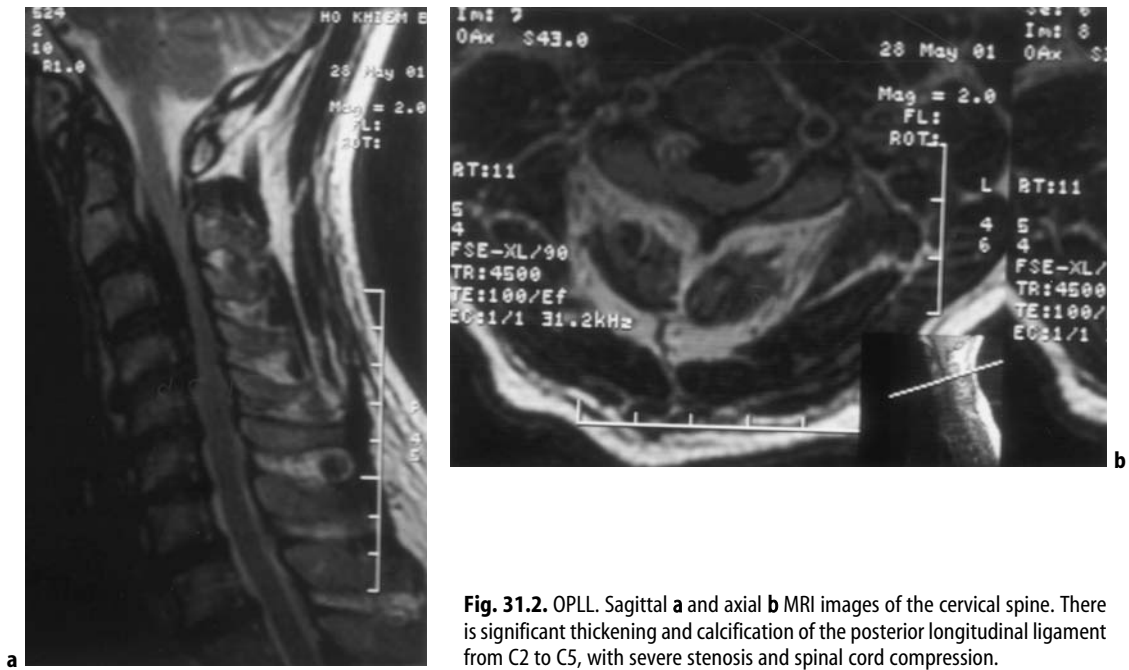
OPLL. Sagittal a and axial b MRI images of the cervical spine. There is significant thickening and calcification of the posterior longitudinal ligament from C2 to C5, with severe stenosis and spinal cord compression.
